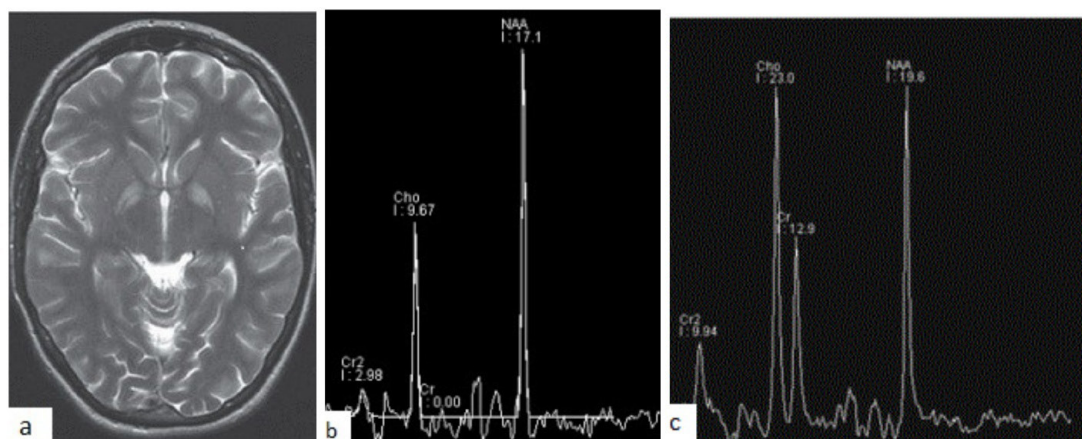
a. MRI brain axial T2W image showing bilateral hyperintensities in globus pallidi. b. MRS showing absent creatine peak. c. normal MRS for comparison
